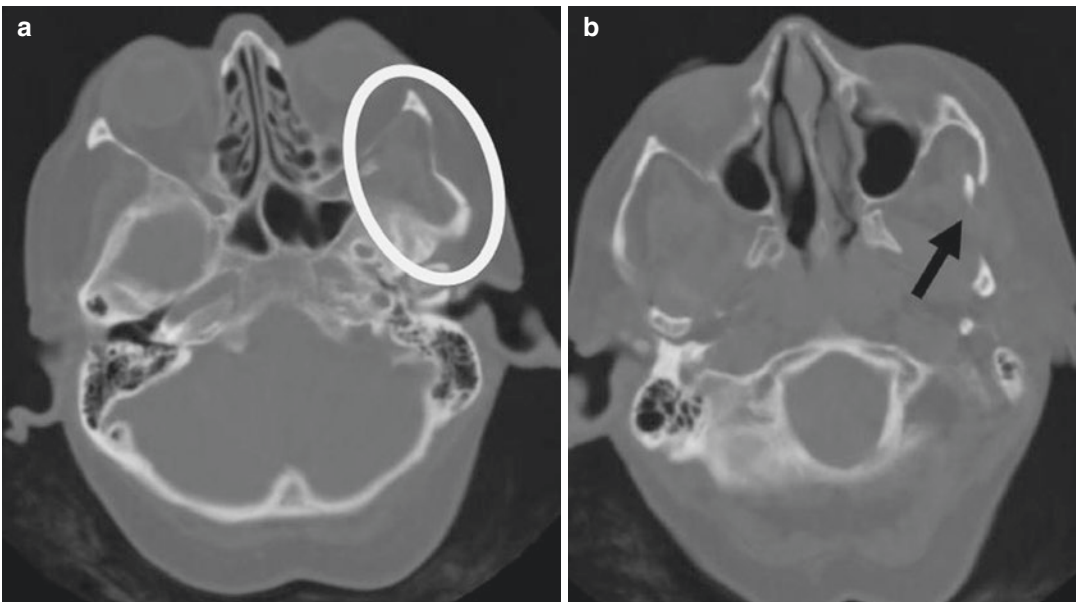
Axial CT scan: multi-fragmentary fracture of the right maxillary bone (a, b) (white circle and black arrow)
